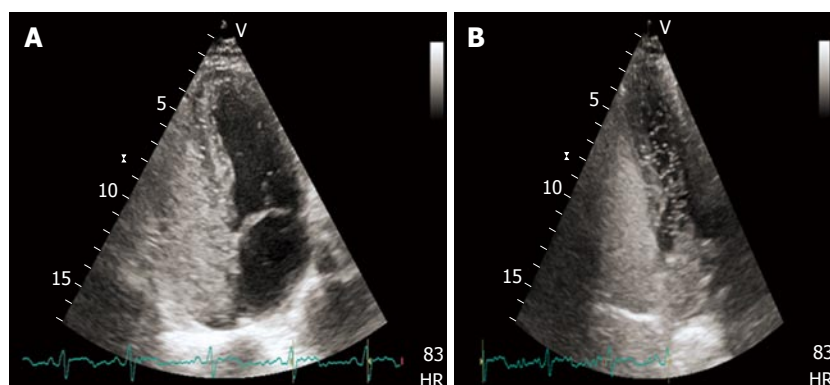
Transthoracic echocardiography showing high grade right to left shunt with evident micro-bubbles in the left heart after intravenous contrast administration (A and B).
